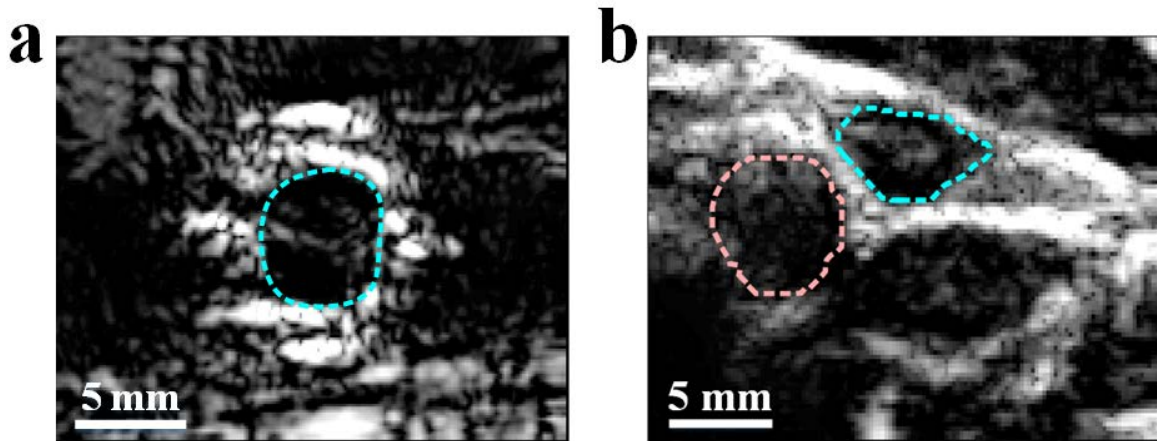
Ultrasound B-mode images showing (a) short-axis view of the PVA-based straight tube with the vessel lumen flow region highlighted with blue dashed circle. (b) cross-sectional view of the *in vivo* Common Carotid Artery (CCA) flow region (red dashed circle) and Jugular Vein (JV) flow region (blue dashed circle).
